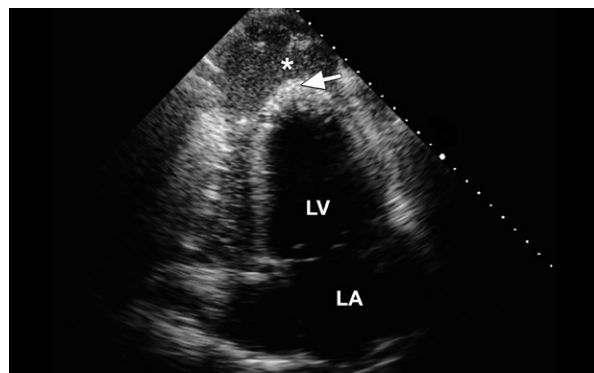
Transthoracic echocardiogram (apical 4-chamber view) shows an echogenic fluid collection in the pericardial space (asterisk), a thickened left ventricle (LV), and a dilated left atrium (LA). The thickened, hyperechoic structure at the apex (arrow) is the pericardial patch from the previous Dor procedure. The LV function is reduced, and there is no evidence of communication between the LV apex and pericardial space.
